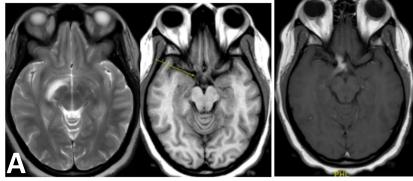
MRA revealed a right optic glioma. MRI of the brain and orbits found abnormal contrast enhancement and T2 hyperintensity involving all segments of the right optic nerve (arrow) and proximal right optic tract, suggesting severe optic neuritis.
